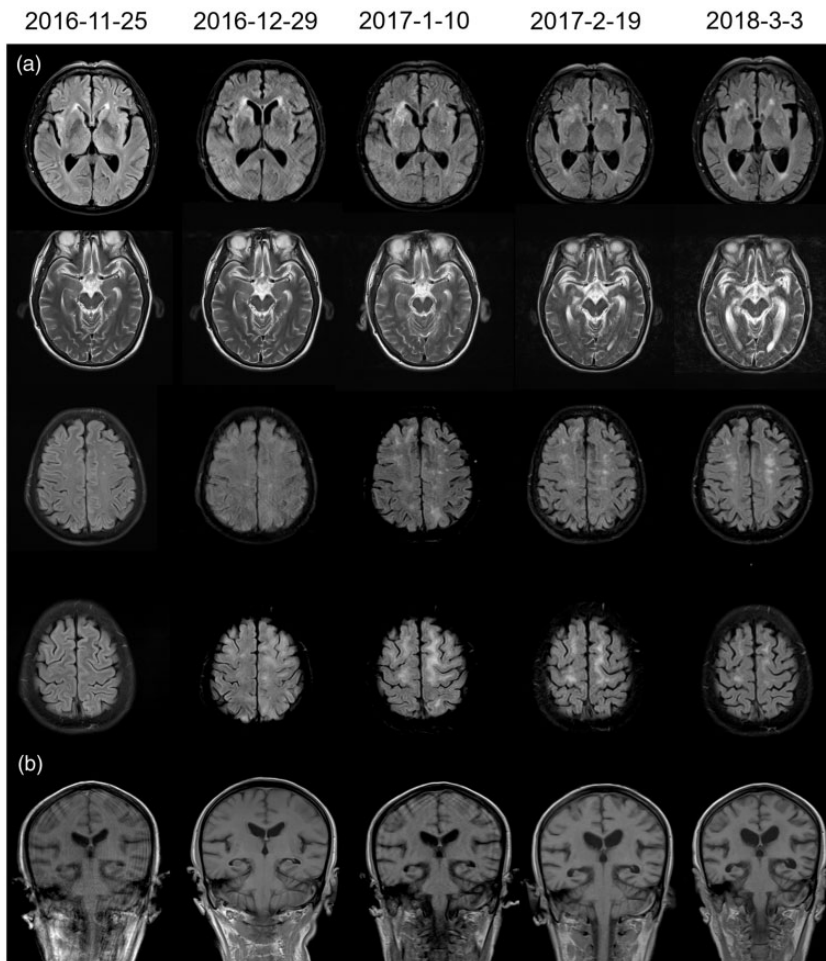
Magnetic resonance imaging (MRI) scans of a 66-year-old Chinese male patient who complained of developing myoclonus in the left leg, ataxia and speech difficulties 3 weeks prior to hospital admission on 20 December 2016. The MRI images show the dynamic changes of the lesions and brain atrophy during the follow-up period. (A) Axial head T2-weighted and fluid-attenuated inversion recovery (flair) MRI undertaken in an outpatient clinic on 25 November 2016 prior to hospital admission showed high signals in the bilateral temporal lobe, which had expanded to the basal ganglia, lateral ventricle and white matter by 29 December 2016. After high-dose methylprednisolone and immunoglobulin treatment, the lesions in the basal ganglia and subcortical white matter had gradually disappeared by the MRI scan on 19 February 2017, but bilateral periventricular white matter lesions persisted at the MRI scan on 3 March 2018. (B) The dynamic Coronal T1-weighted MRI from 25 November 2016 to 3 March 2018 demonstrated the enlargement of the lateral ventricle and atrophy of the hippocampus (white arrows) that occurred 3 months after onset of the symptoms and continued to deteriorate during the 1-year MRI follow-up.
